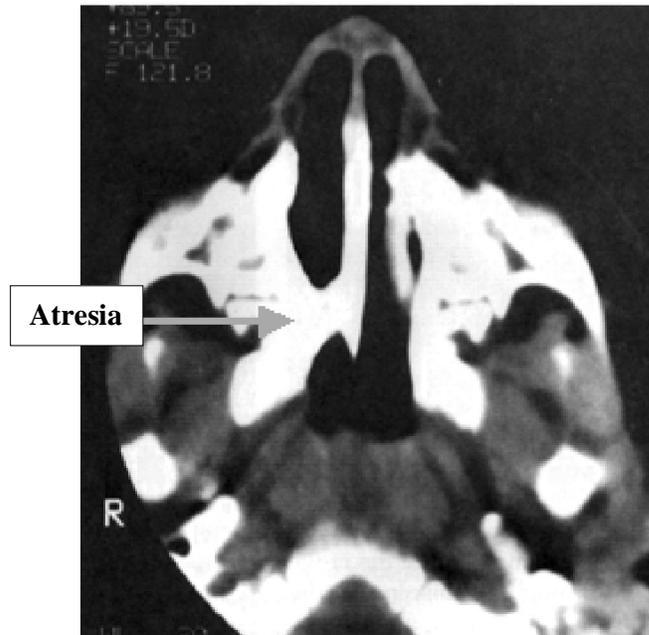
An axial CT scan showing right bony choanal atresia.
